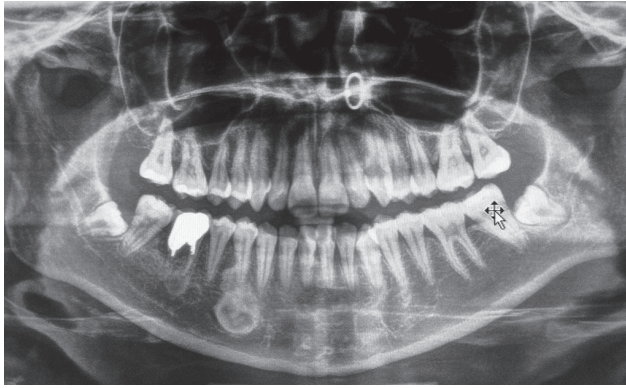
Panoramic radiograph of the patient with an excessive restoration and old endodontic treatment in the right mandibular first molar
